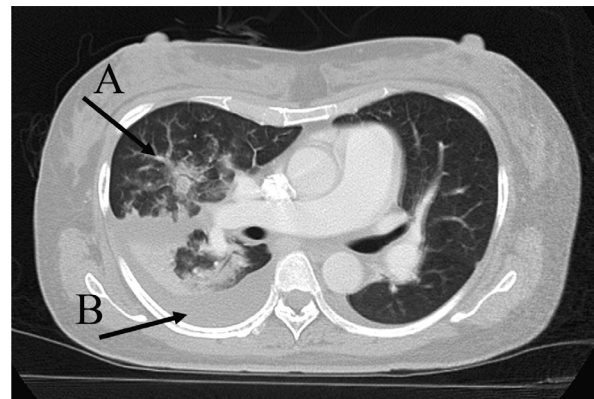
Imaging on arrival at our hospital (contrast-enhanced computed tomography)
